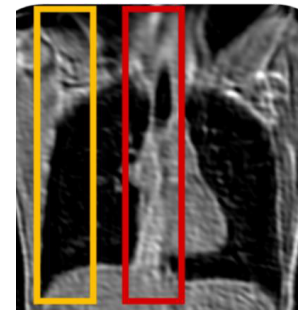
Central slice of a ^1H -MRI survey scan of our healthy volunteer at maximum inspiration, showing ^{19}F -MR ISIS slab locations in regions of lung periphery (yellow) and major airways (red).
